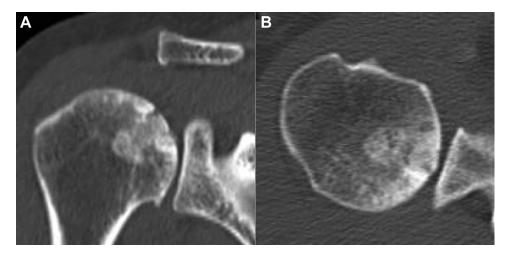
Computed tomography (CT) images 6 months after surgery. CT images showed the graft union. (A) Oblique coronal image of the right shoulder. (B) Axial image of the right shoulder.
